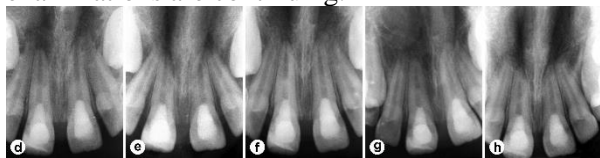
3-month follow-up radiograph revealed formation of a calcific barrier in the middle of the root at Tooth #11
